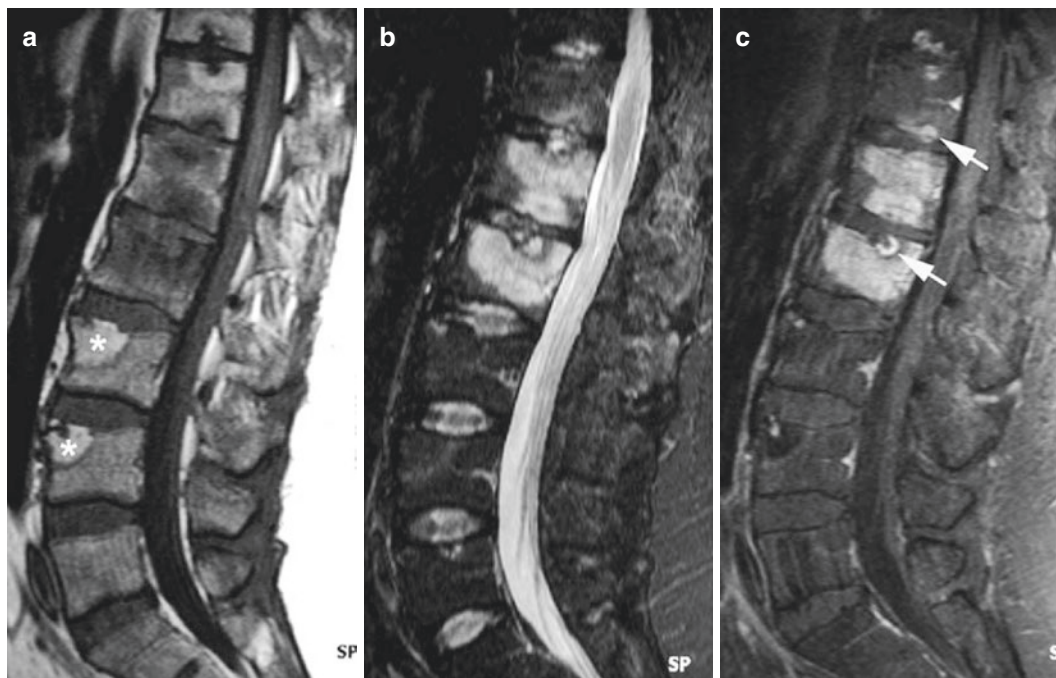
Type I discovertebral lesions (Schmorl's node formation). Sagittal T1-weighted (a), fat-suppressed T2-weighted (b) and gadolinium-enhanced T1-weighted (c) spin echo MR images show signal intensity changes within bone marrow close to the endplates, focal high
